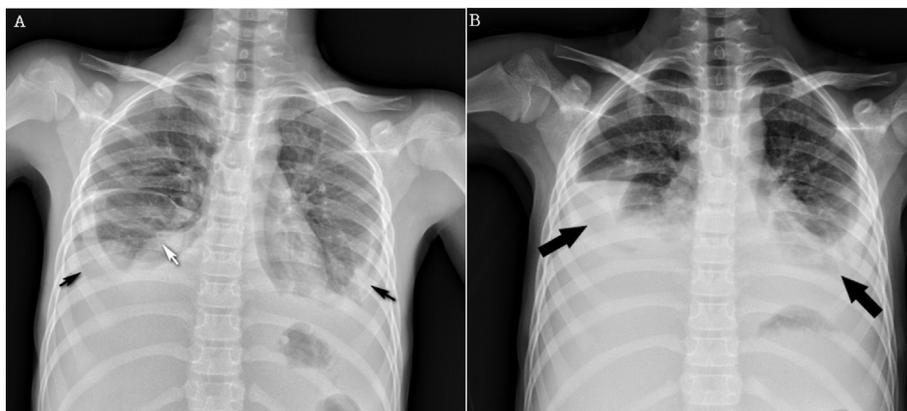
A & B. Chest radiograph revealed bilateral pleural effusion (black arrows) with passive atelectasis (white arrow) and increased infiltration of bilateral lower lobes.
